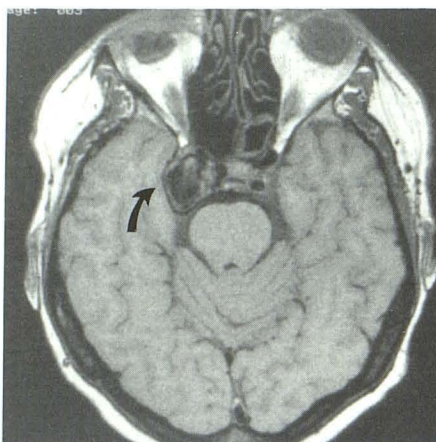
Axial MR image, 600/30, at level of cavernous sinus shows dilatation of right cavernous sinus and large area of decreased signal suggestive of flowing blood (*arrow*). Left internal carotid artery is well shown.
